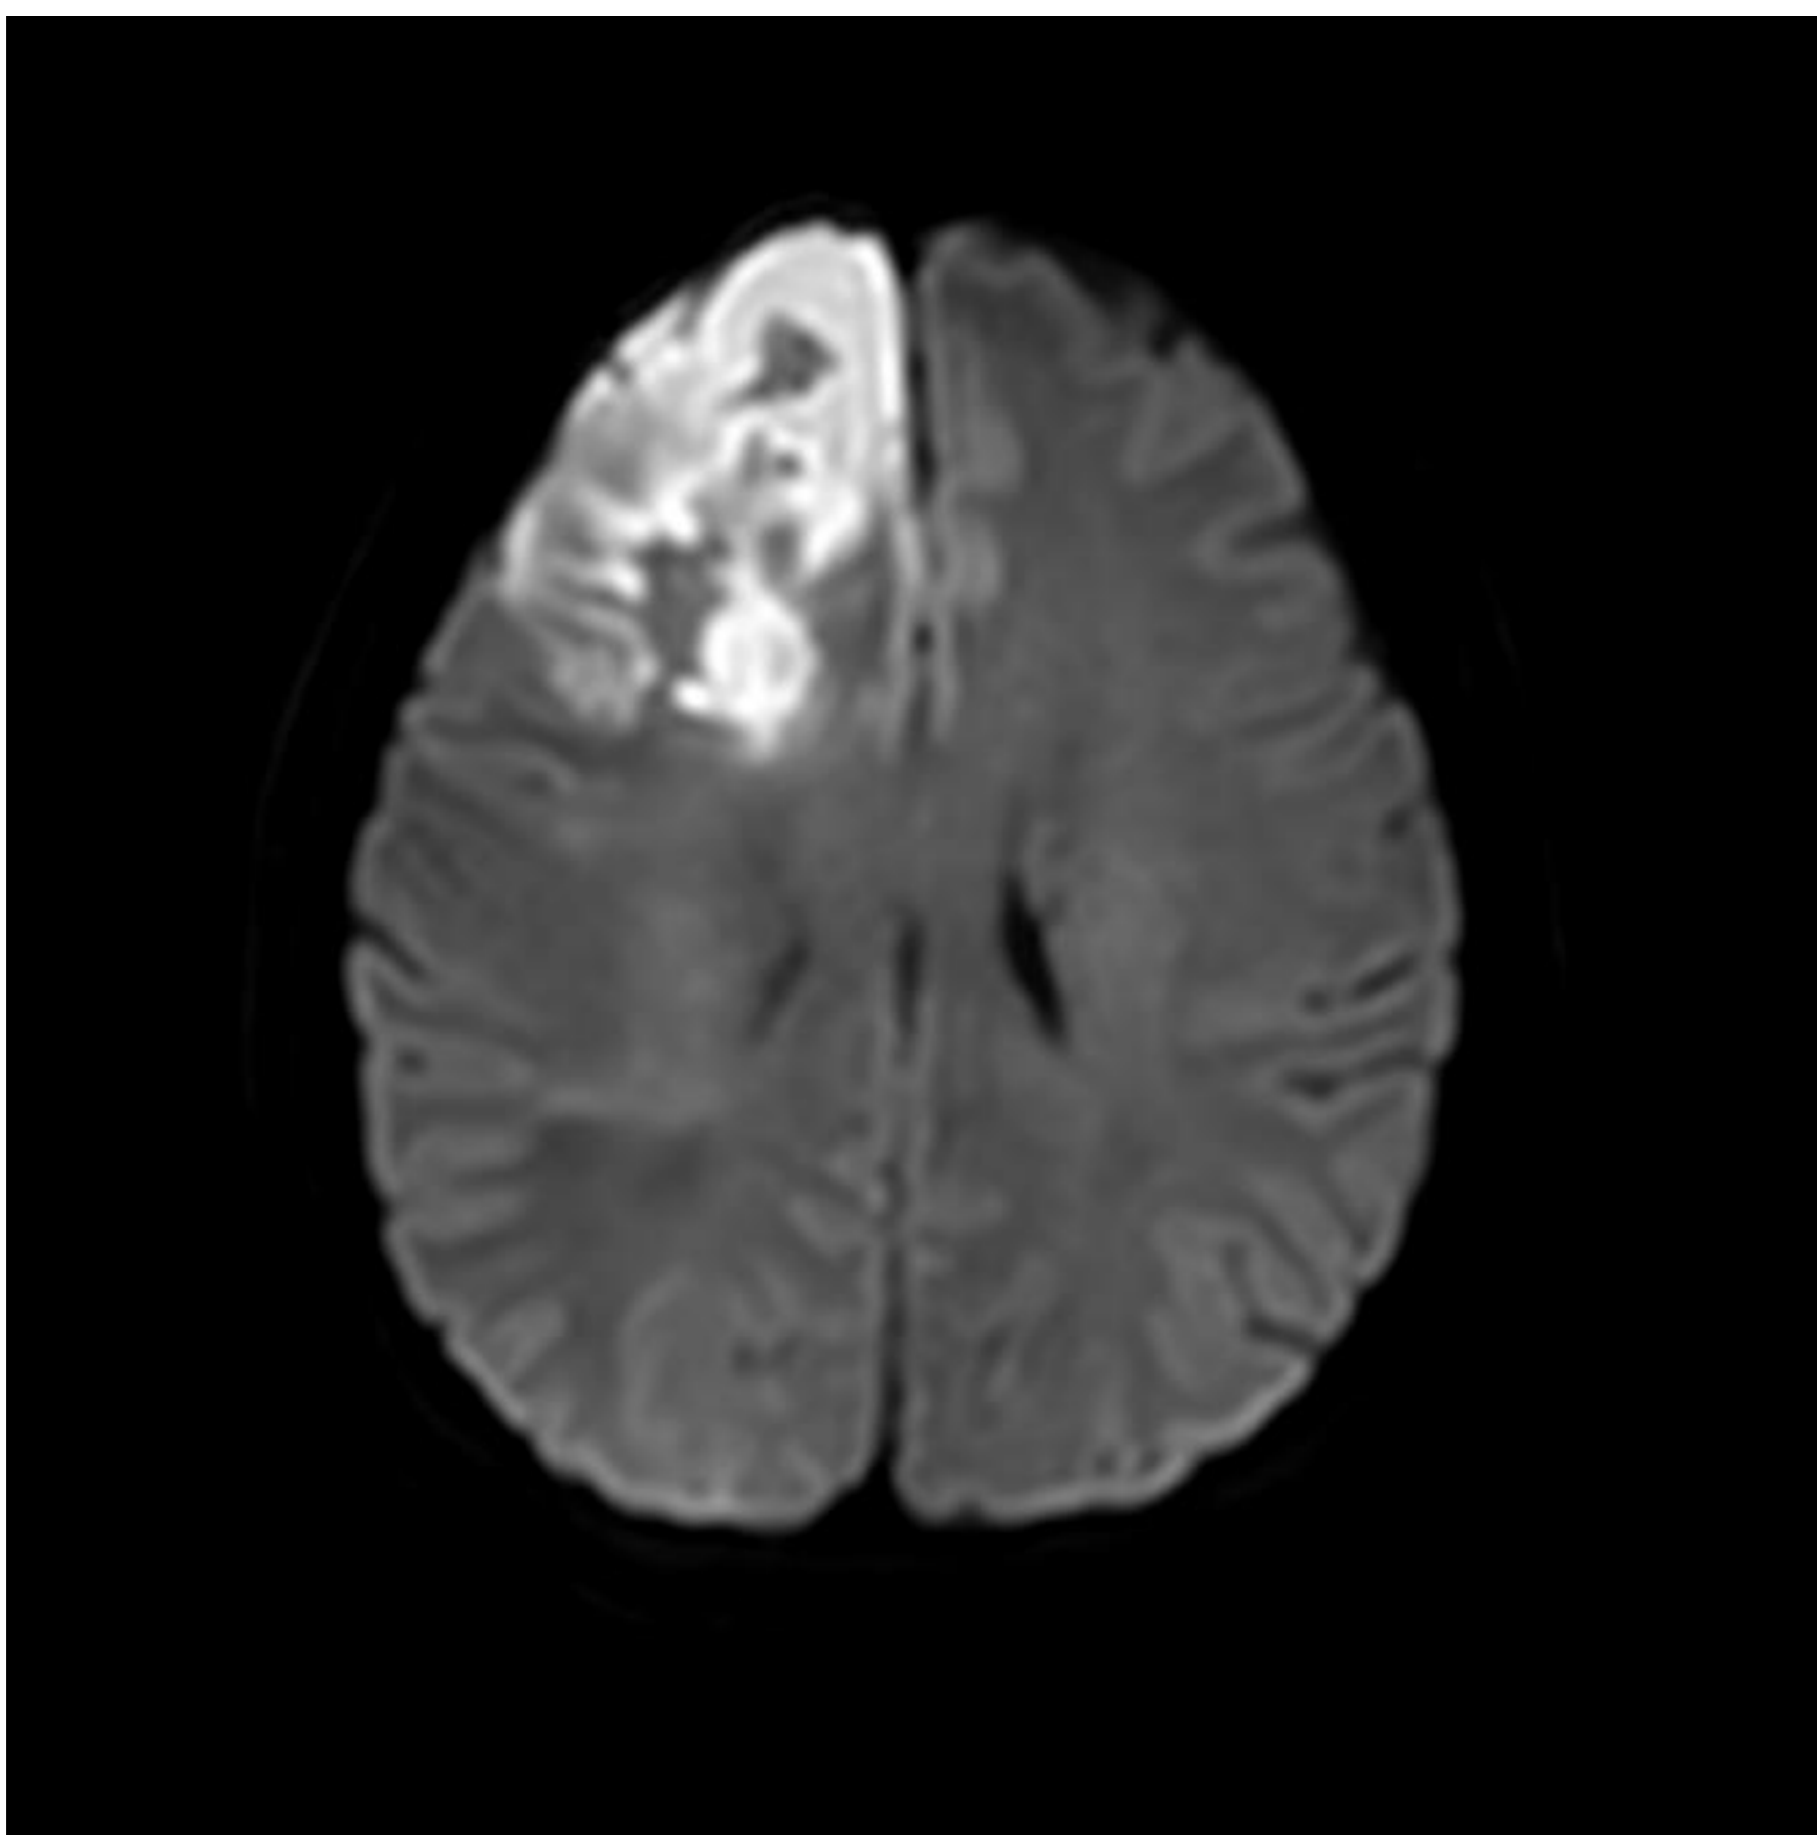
Brain MRI showing an acute infarction in the right medial frontal lobe, DWI sequence
